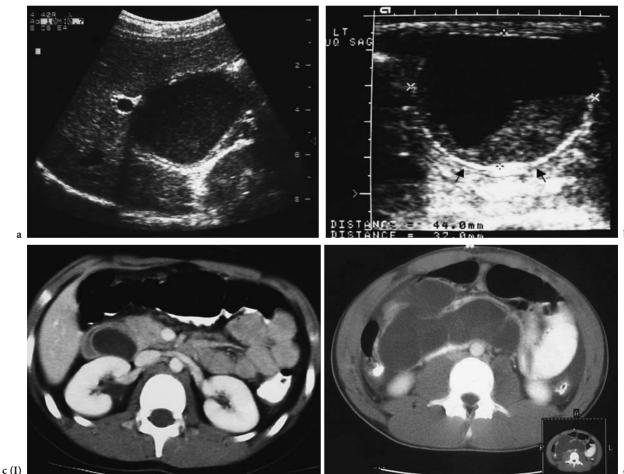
a A non-communicating duplication cyst of duodenum. Note the echogenic mucosal layer and hypoechoic muscular layer and the inhomogeneous content of the cyst. b Colonic duplication. US demonstrates mucosal echogenic "stripe"(*arrows*). c (I) & (II) CT of colon duplication
